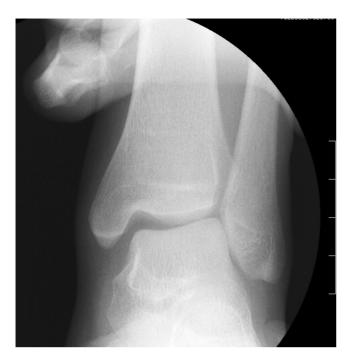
Preoperative valgus stress radiograph showing an increased talar tilt angle.
